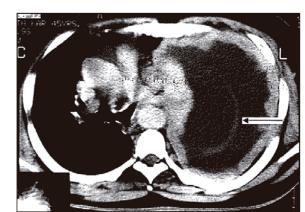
Axial CT image shows gross left-sided pleural effusion, nodular pleural thickening and septations (arrow).
